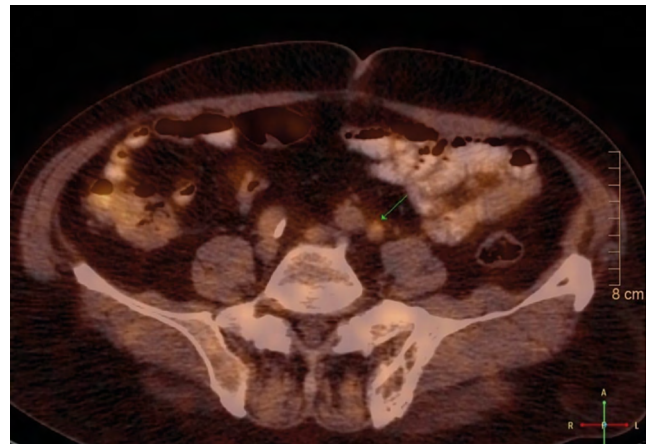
A follow-up [^{18}F]FDG PET/CT study of a patient with CM of the right gluteal skin region after recurrent right inguinal LNs, pT2a pN1b cM0. Seven months after regional progression a small distant left common iliac LN was detected, not recognized on follow-up CT
